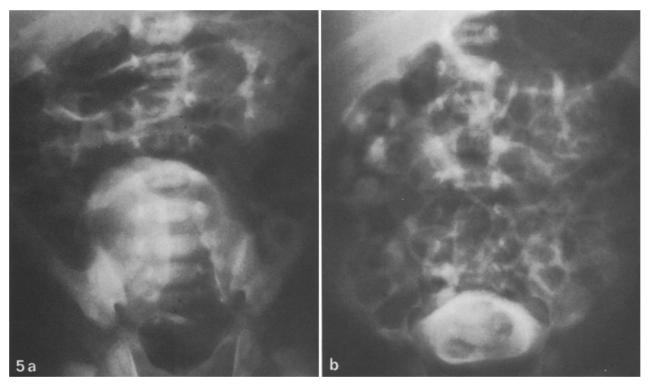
a and b. Ectopic ureterocele. a "Prone radiograph" in a child with right duplex collecting system and ectopic ureterocele. The ureterocele is not seen. b "Supine radiograph" clearly shows the ureterocele as a filling defect in the base of the bladder
